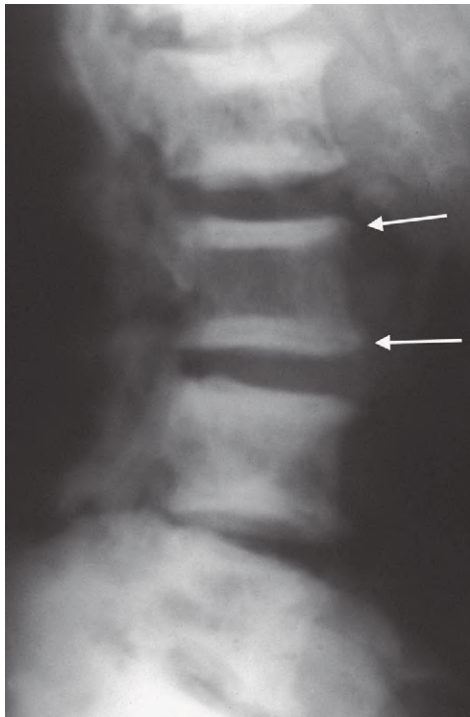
Lateral radiograph of the spine in a patient with chronic renal failure. Characteristic endplate sclerosis (arrows) are referred to as ‘rugged-jersey spine’ (reproduced by kind permission of Dr M. J. Kline, Department of Diagnostic Radiology, Cleveland Clinic Foundation).
